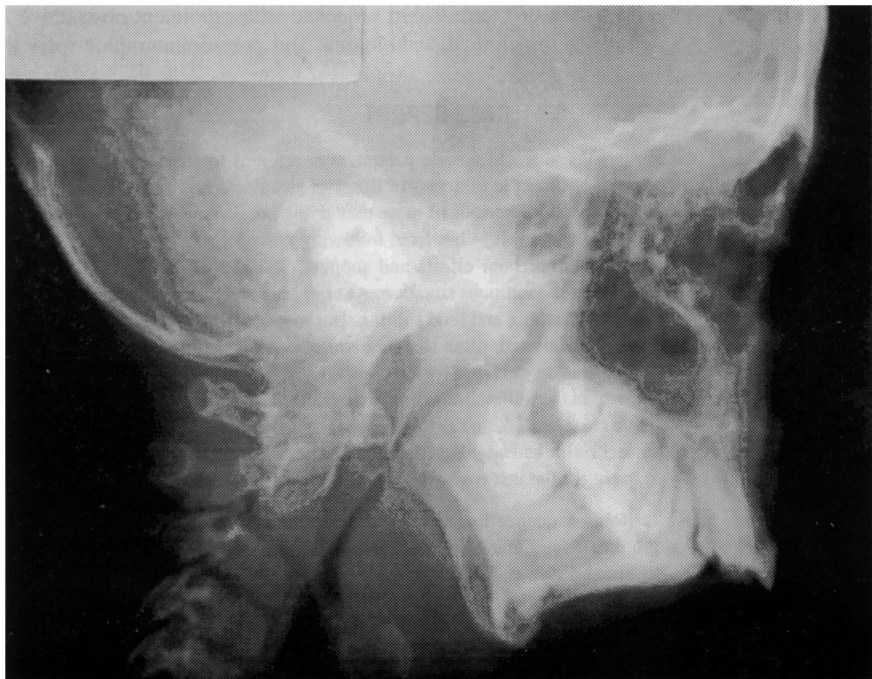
Case A, cephalometric roentgenogram. Micrognathia with marked posterior airway space (PAS) reduction.
